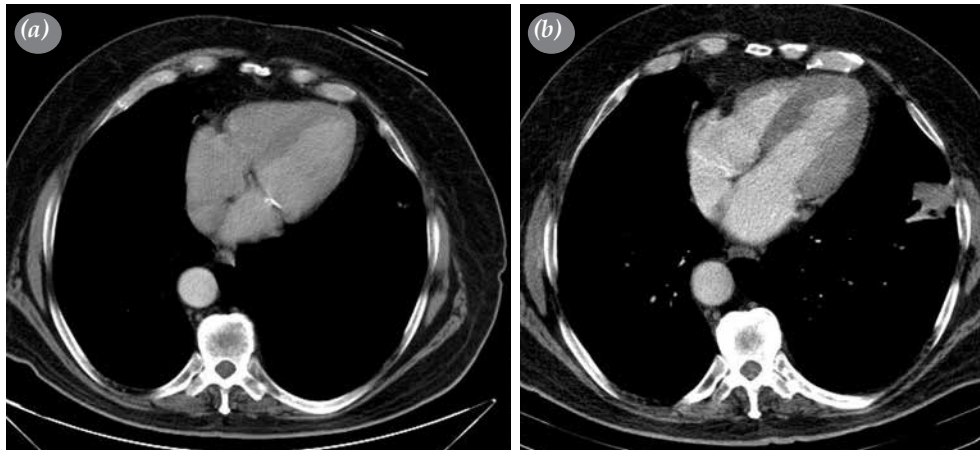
(a) Contrast-enhanced chest computed tomography one year and just before surgery. (b) There was a 1 cm nodule at left lower lobe of lung, which was measured as 3.5 cm in diameter after one year.
